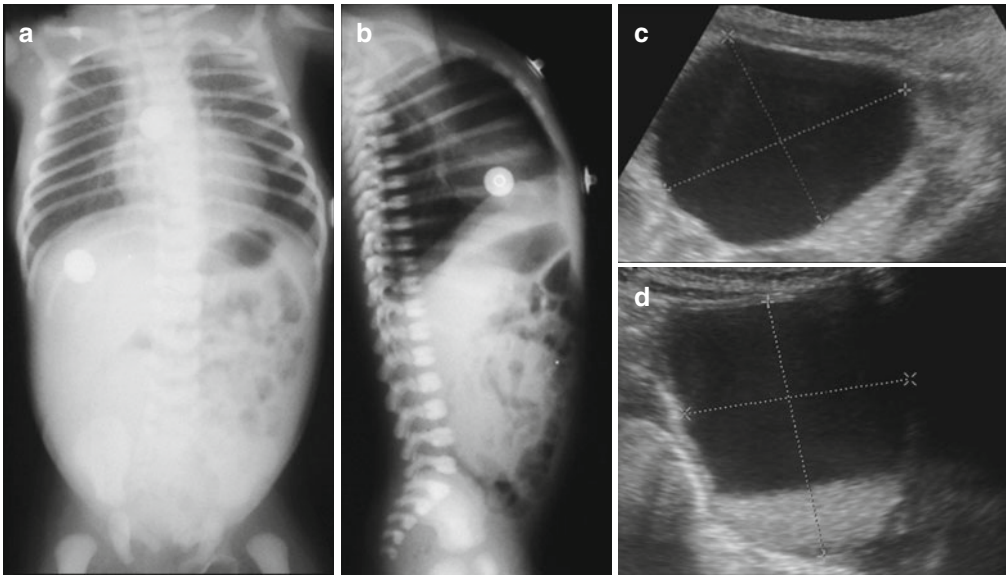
(a, b) Abdominal radiograph of a 1-month-old girl with vomiting, fever, abdominal distension; the X-ray raises the suspicion of a right abdominal mass displacing
